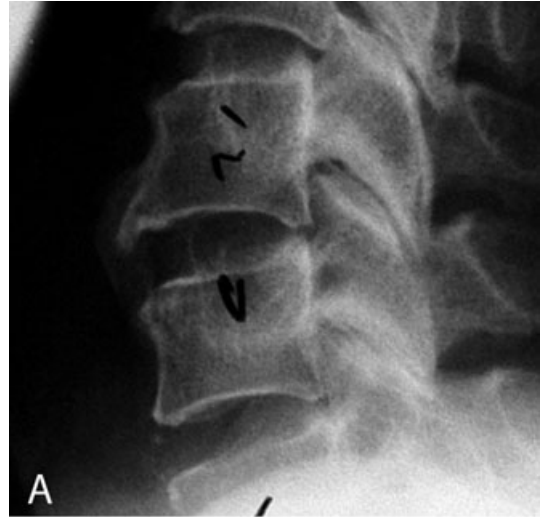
Comparison of antemortem and postmortem radiographs. (A) Antemortem radiograph of L.K.'s cervical vertebra (anterior is to left; black markings are result of hospital radiograph examiner). (B) Postmortem radiograph of cervical vertebrae 5 and 6 of the found skeletal remains (anterior is to left). White and black arrows indicate locations of morphological consistency between L.K. and the unidentified male.
